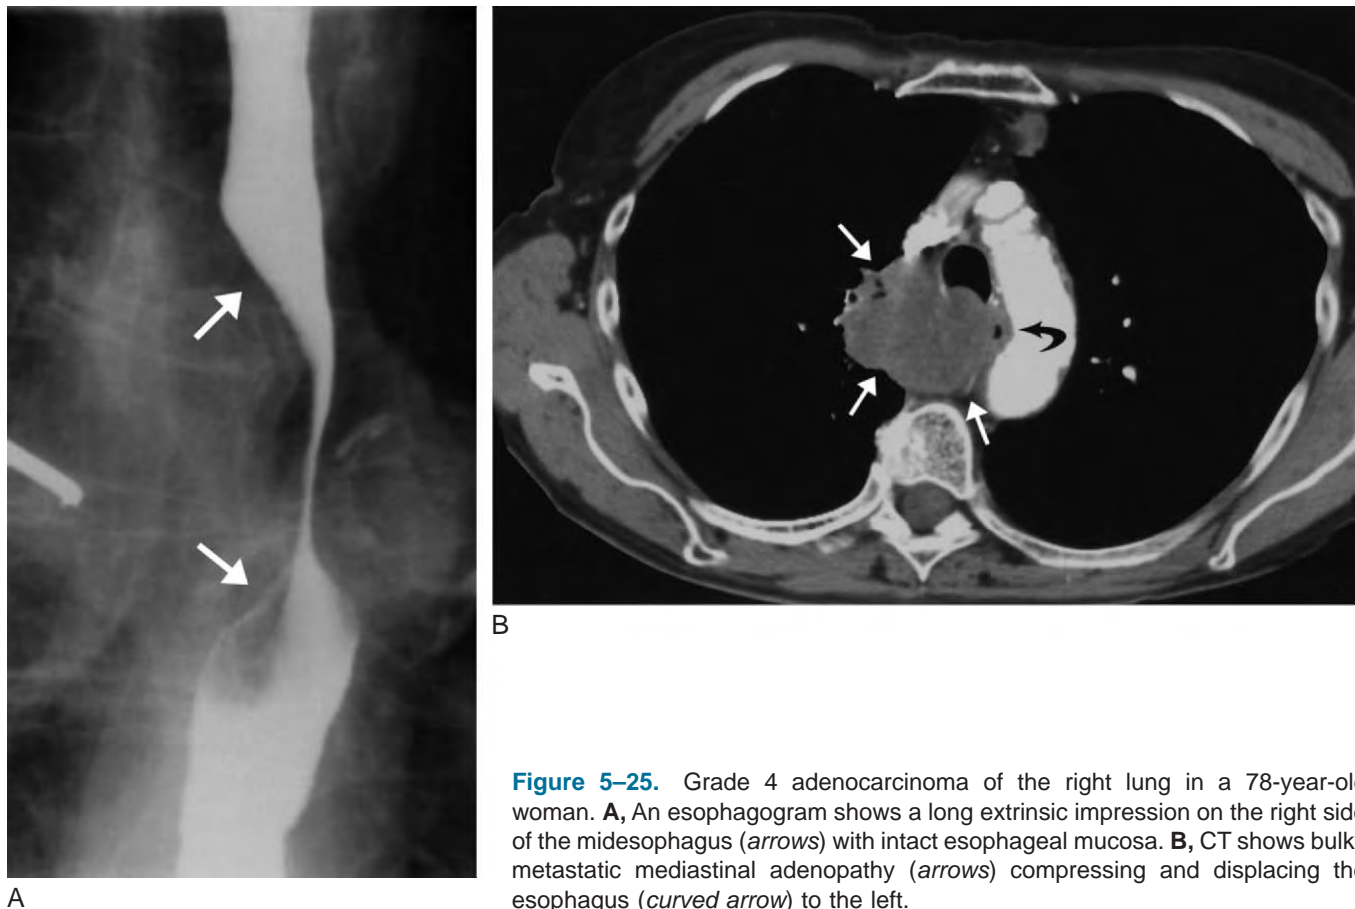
Grade 4 adenocarcinoma of the right lung in a 78-year-old woman. A, An esophagogram shows a long extrinsic impression on the right side of the midesophagus (arrows) with intact esophageal mucosa. B, CT shows bulky metastatic mediastinal adenopathy (arrows) compressing and displacing the esophagus (curved arrow) to the left.
